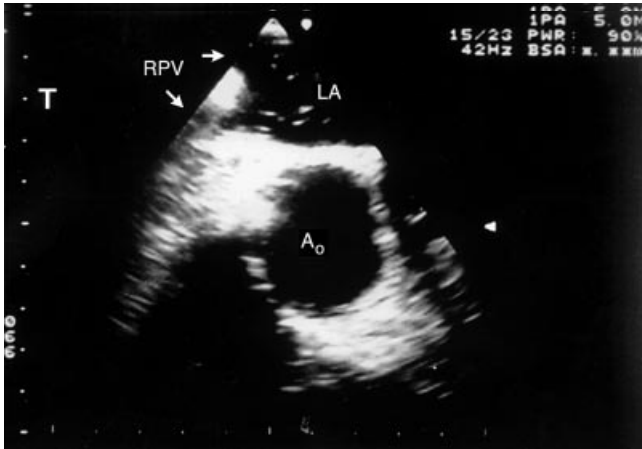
Short-axis view at the level of mid-oesophagus transoesophageal echocardiogram showing the right pulmonary vein (RPV), left atrium (LA), and aorta (AO). About 5 min after the reduction of end-tidal CO_2 , air bubbles were seen within the RPV as they entered the LA, indicating a right-to-left pulmonary shunt.
